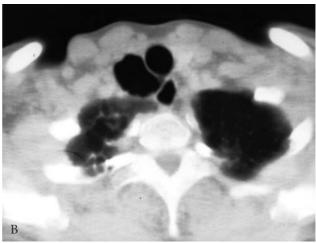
Tracheal cyst. Anteroposterior tomogram (A) and computed tomography scan of the upper trachea (B) demonstrate a thin-walled air-filled right paratracheal cyst.
